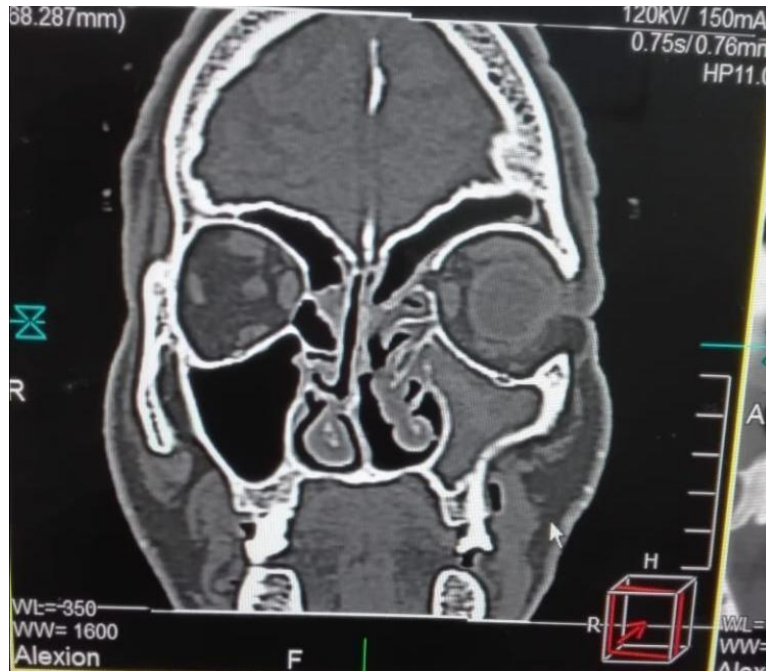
shows 35 years old female coronal CT with chronic sinusitis in Lt maxillary sinuse
